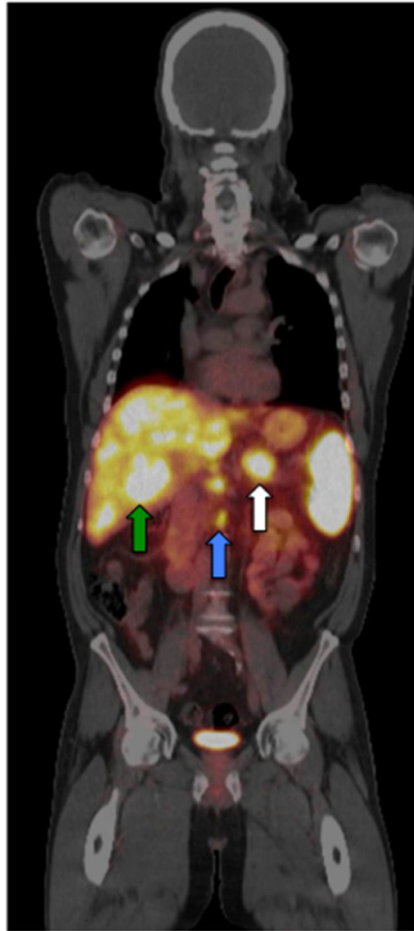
^{68}Ga -DOTATOC PET/CT of a patient with innumerable hepatic metastases (green arrow), lymph node metastases (blue arrow) and a primary PNET (white arrow). Physiologic uptake is seen in the spleen.
